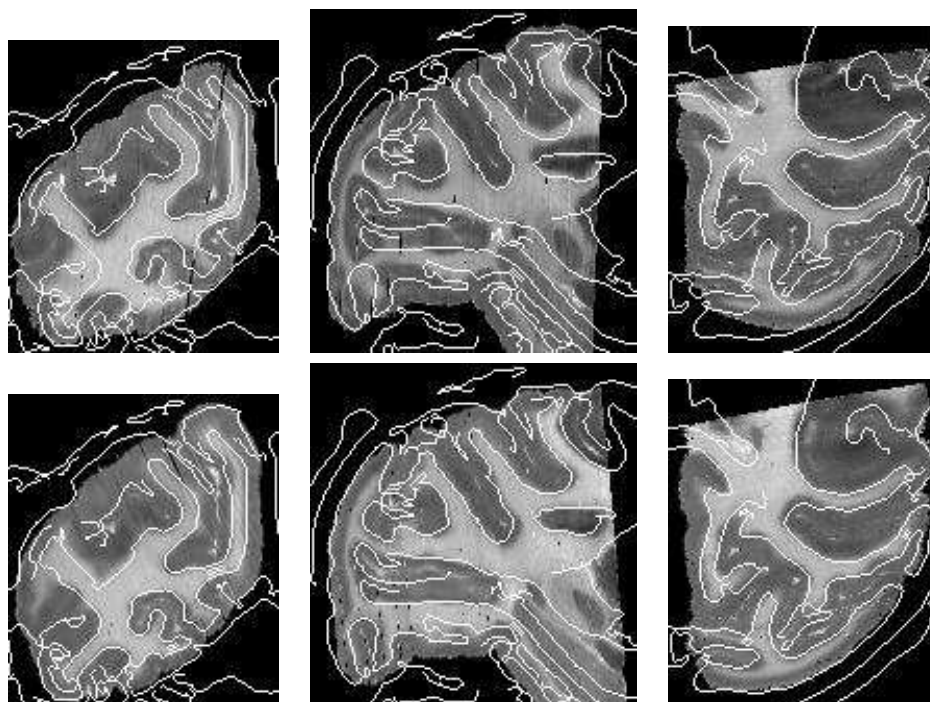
The contours extracted from the MR image (first row of figure 8) superimposed on the corresponding slices of two bottom rows from the same figure.
